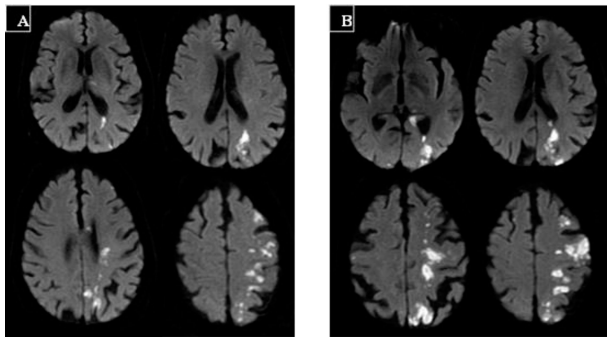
Findings on MRI: DWI performed (A) at admission and (B) at day 2 after symptom onset revealed an increased number of lesions in the left middle cerebral artery–anterior cerebral artery and left middle cerebral artery–posterior cerebral artery watershed territories (arrowheads) as well as the left middle cerebral artery territory along the cerebral convexity (arrow). All DWI lesions showed concomitant decreases in the apparent diffusion coefficient map consistent with ischemia (not shown).
